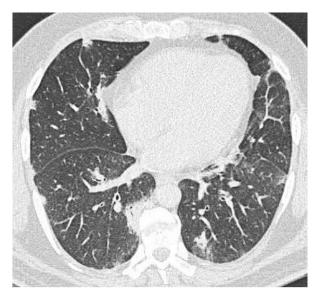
High-resolution CT scan of the chest of a 48-year-old man with HES (case #8, Table 1) demonstrating predominantly peripheral opacities of consolidative and ground-glass character in a patchy distribution.
